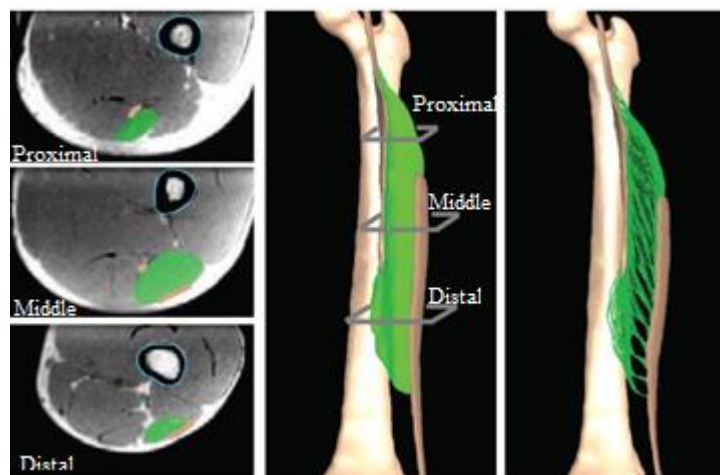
MRI-based model of the hamstring from Rehorn et al. (2010). This model is defined via MRI data to provide an accurate geometry of the aponeurosis region's fibres, making it individual specific.
